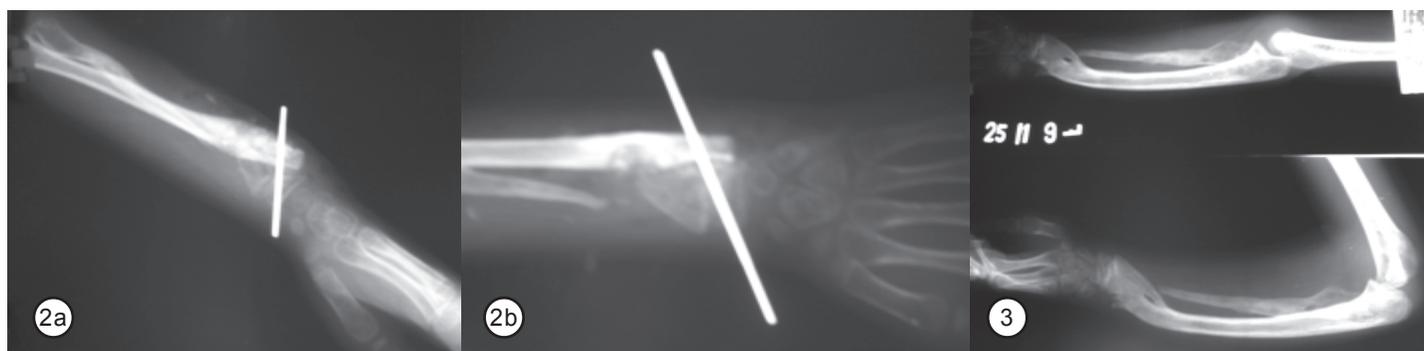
Post-operative radiographs showing resection of distal ulnar stump and synostosing the distal radio-ulnar articulation
